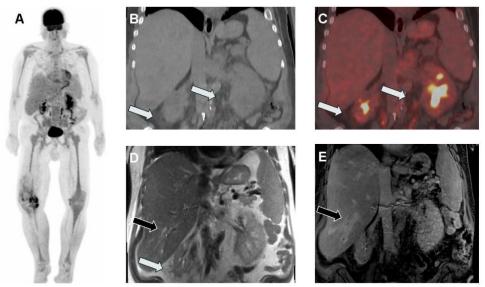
PET/CT and MRI of concurrent MDS and ECD. (A) FDG PET/CT maximum intensity projection demonstrating hepatosplenomegaly and diffuse FDG uptake in the bone marrow. Coronal slices from PET/CT reveal perinephric and retroperitoneal fat stranding (B) without FDG uptake (C). Coronal slices of T2-weighted MRI also show perinephric fat stranding (D, white arrow) and peripheral biliary dilation (D, black arrow) further detailed post-contrast with biliary wall thickening and enhancing peribiliary soft tissue (E, black arrow).
